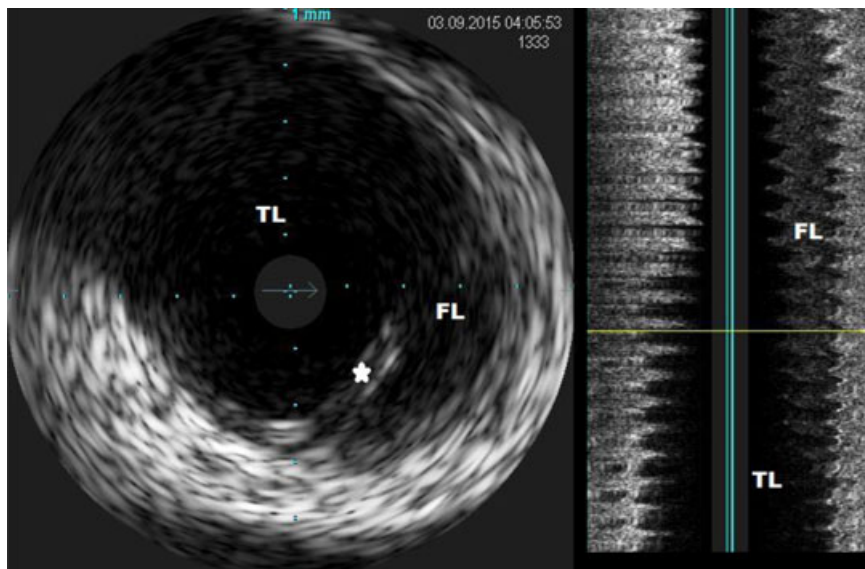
Intravascular ultrasound images of dissection entry site with intimal flap (marked with an asterisk) in the left main coronary artery. FL, partially thrombosed false lumen of dissected LMCA; LMCA, left main coronary artery; TL, compressed true lumen of LMCA²³ [Color figure can be viewed at wileyonlinelibrary.com]
